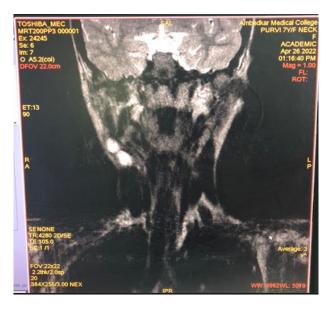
MRI neck showing a bilobulated thin-walled cyst like lesion.
